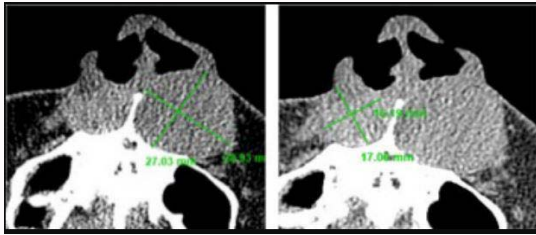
CT scan presentation.
